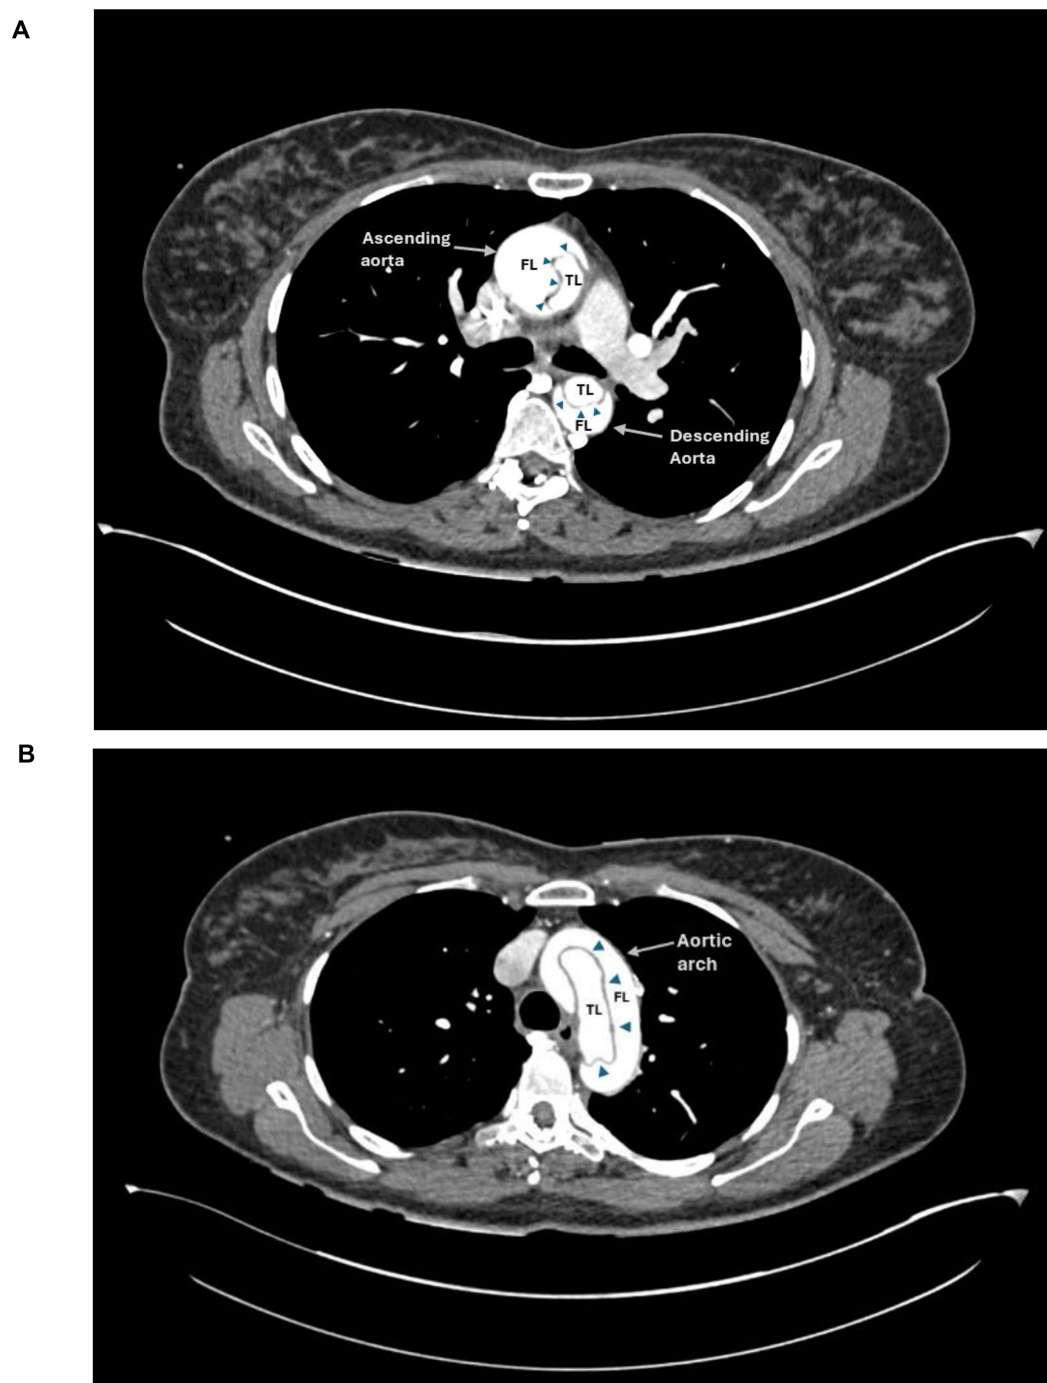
Case 1 type A acute aortic dissection computed tomography aortogram images. Axial slices from computed tomography aortogram demonstrating type A acute aortic dissection at the level of the ascending and descending aorta (A) and the aortic arch (B) as described in Case 1. Blue arrowheads show the intimal flap separating the true and false lumens. Abbreviations: TL, true lumen; FL, false lumen.
